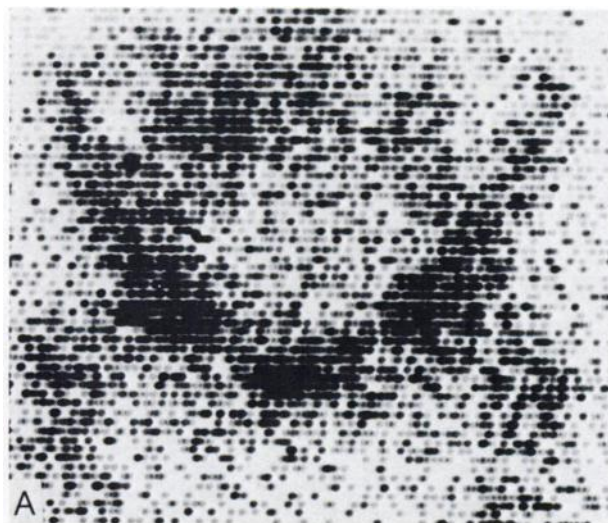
Thirty-five-year-old female patient studied to exclude breast metastases to bone. A is ^{85}Sr scan of pelvis showing increased activity in right sacroiliac area. B is x-ray showing large-bowel shadow in same region. C is ^{85}Sr rescan several days later; activity in right sacroiliac area remains unchanged. D is pelvic tomograph showing lytic lesion in right ilium.
